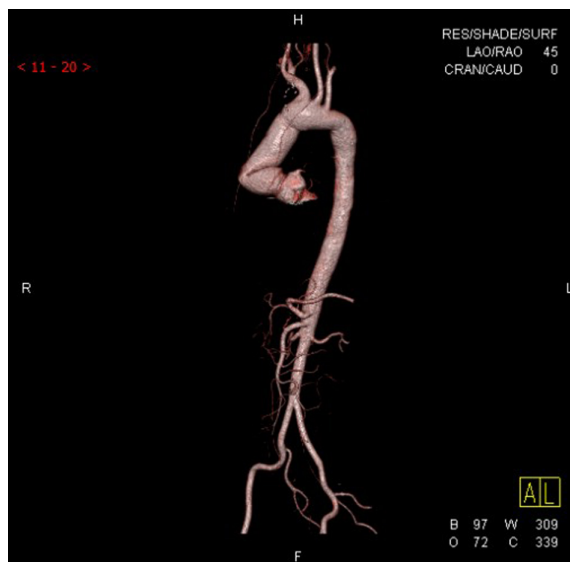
The 3D reconstruction by CT revealed the severely kinked graft. CT, computed tomography.
